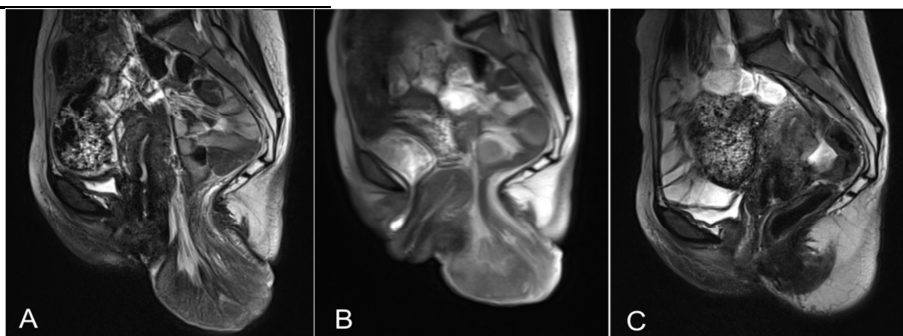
Preoperative appearance. Fig. 2. Pelvic magnetic resonance imaging (MRI) in the sagittal plane, T2-weighted scans. A. Prolapsed tissues at rest, preoperatively. B. Prolapsed tissues at strain, preoperatively. C. Postoperative appearance at 6-months follow-up.
